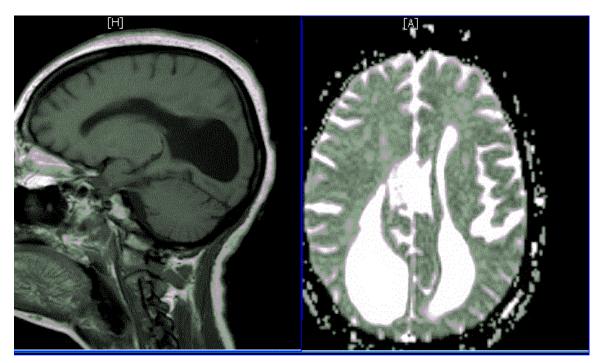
MRI brain showing colpocephaly and corpus callosum agenesis
